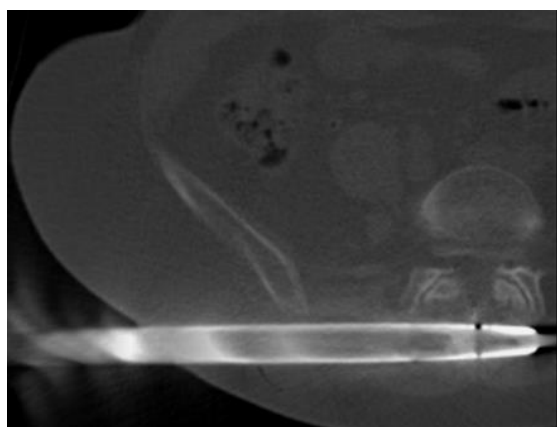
Intraoperative control CT scan.
